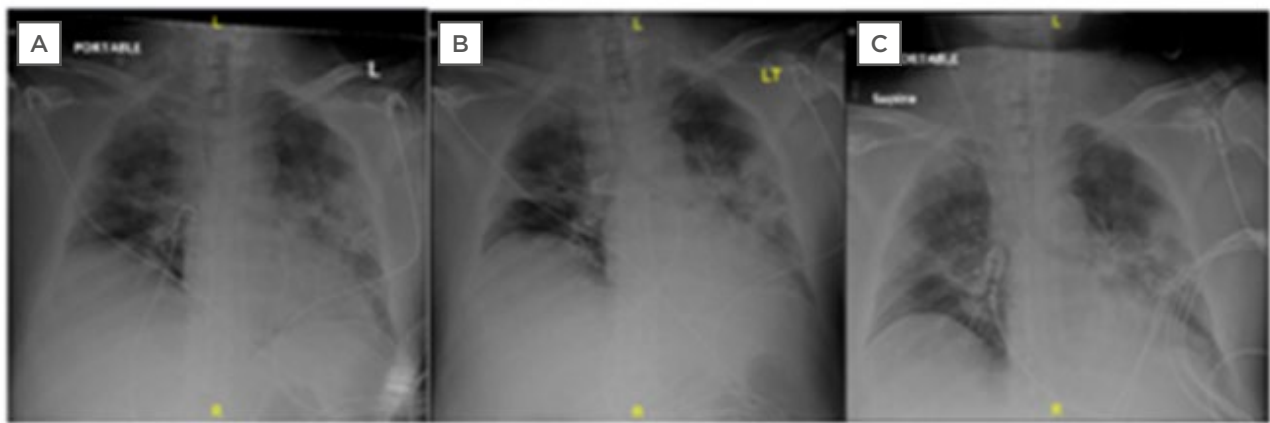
Series of chest radiographs following intubation in the emergency department. A) 22nd March 2020, at 4:27:11. B) Half an hour post-intubation (22nd March 2020, at 5:08:38). C) Approximately 4 hours post-intubation in the intensive care unit before transfer (March 22nd 2020, at 8:10:30).
